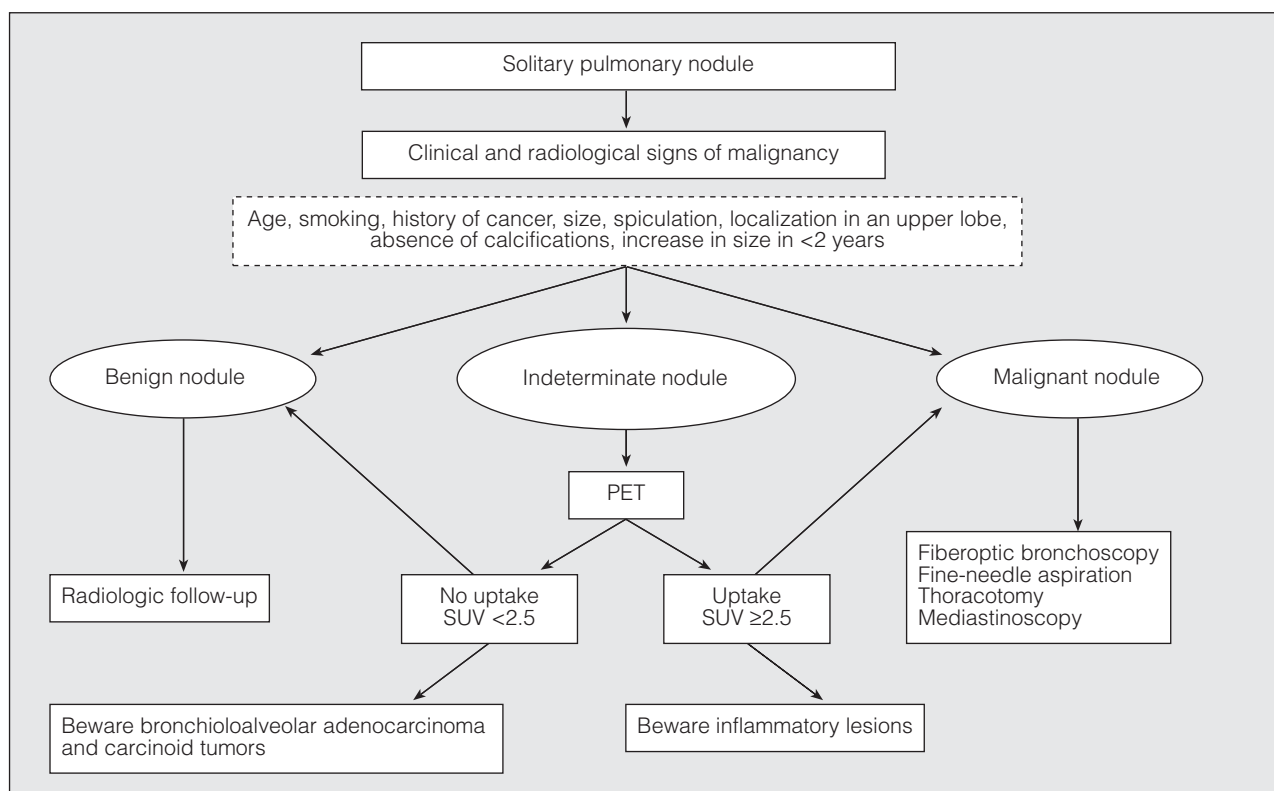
Diagnostic algorithm for the solitary pulmonary nodule highlighting the role of positron emission tomography (PET). SUV indicates standardized uptake value.
